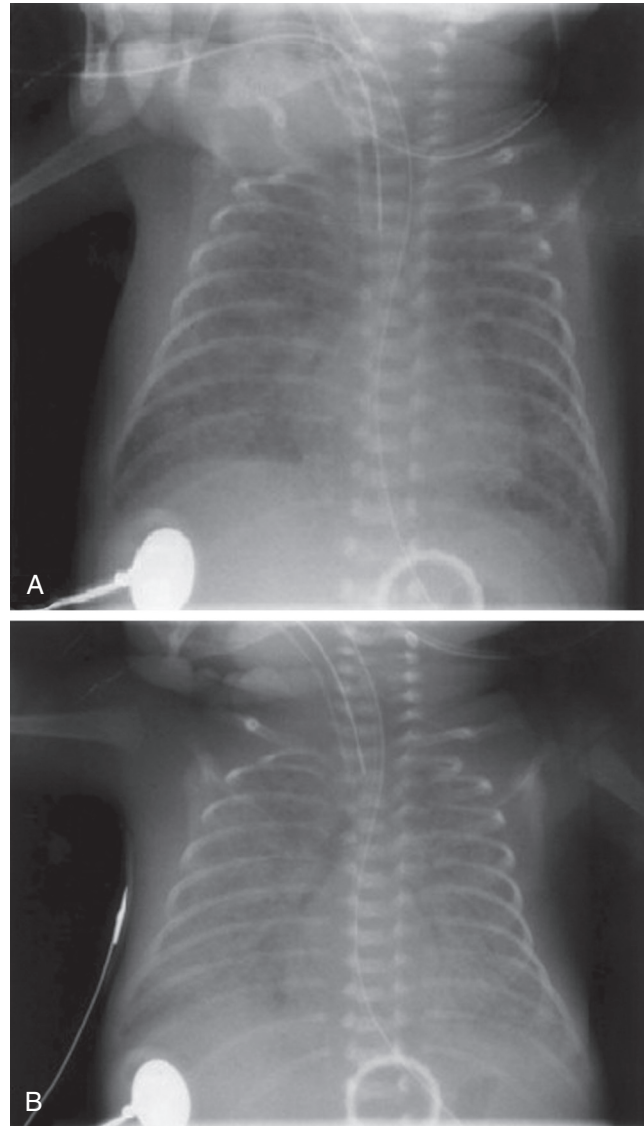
Chest X-ray of preterm infant (24 weeks of gestation) with severe respiratory distress syndrome (A) just before and (B) after pulmonary hemorrhage. (From Narasimhan R, Papworth S. Pulmonary hemorrhage in the neonate, *Paediatr Child Health* 2009; 19:171.)
